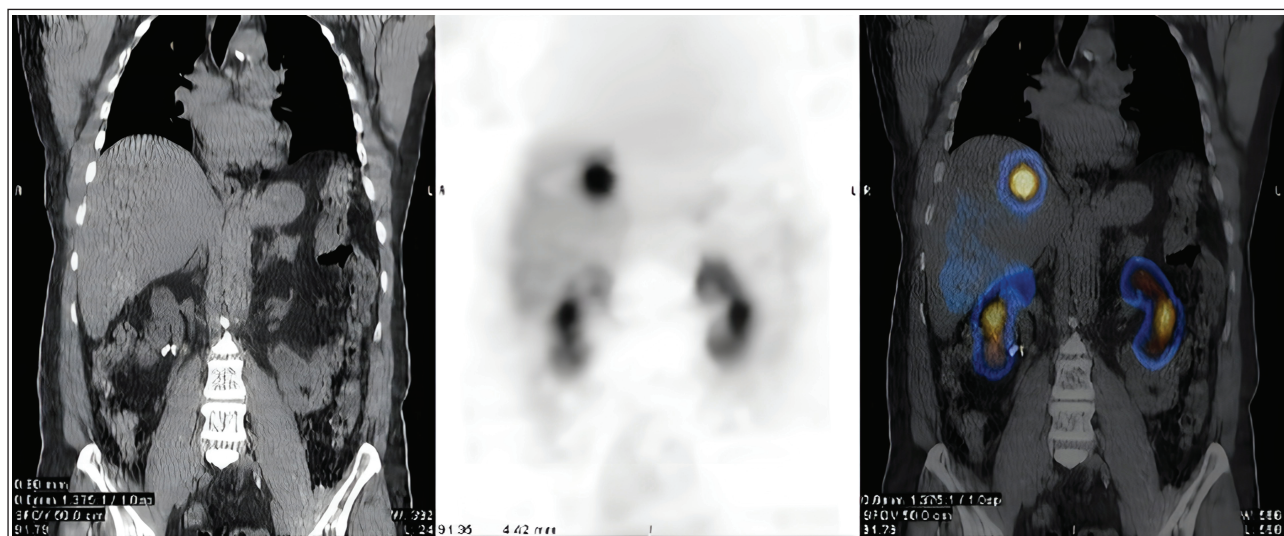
SPECT CT images of baseline [^{99m}Tc]Tc-HYNIC-TATE scan acquired in July 2023, showing a well-circumscribed solitary focus in segment VII of liver.
